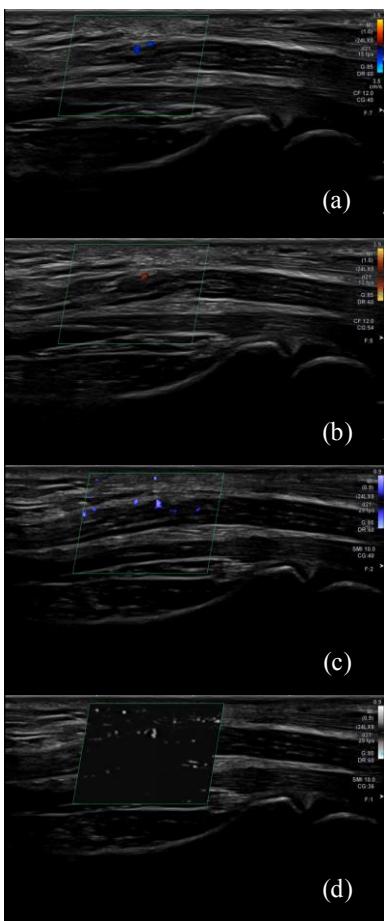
Evaluation of vascular features for a CTS patient using (a) Color Doppler Imaging (b) Power Doppler Imaging (c) Monochrome Superb Microvascular Imaging (d) Color Superb Microvascular Imaging.
